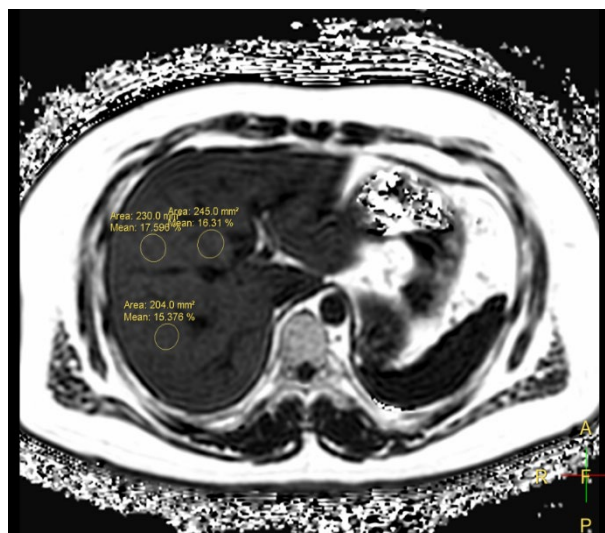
FF quantification performed using Philips workstation (PHILIPS-KL93MGI, Windows 10 Enterprise 2016 LTSB 64-bit). Circular ROIs (n=3) placed on Dixon images at anatomically matched liver sites corresponding to ultrasound measurements, avoiding vessels, bile ducts, cysts, and calcifications. FF value calculated automatically by the system; mean of three ROIs recorded as final FF positioned at similar depth for consistency and reproducibility.
